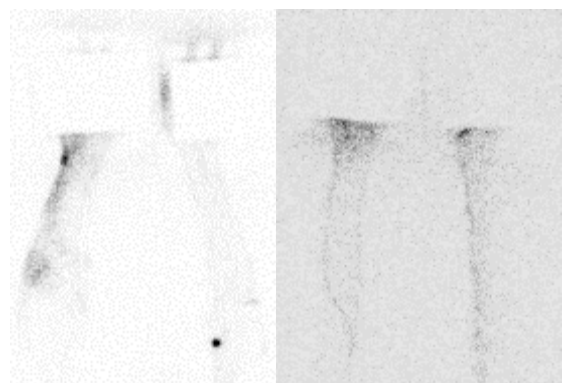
Preoperative (left) and postoperative 1 year (right) upper extremity lymphoscintigraphy. Compared with the preoperative findings, the 1-year postoperative study demonstrates a substantial improvement in lymphatic function, characterized by decreased dermal backflow and more efficient proximal tracer migration.
